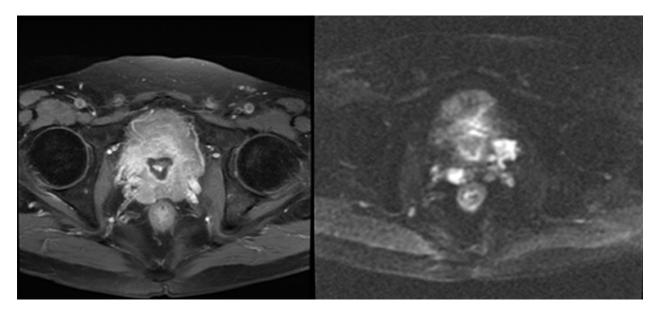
Pelvic MRI before chemotherapy: status post TURBT of urinary bladder and TURP of the prostate. Wall thickening and heterogeneous enhancement are noted in urinary bladder. Also an abnormal soft tissue on the left pelvic floor; which is suspected to be a residual tumor or metastasis.
